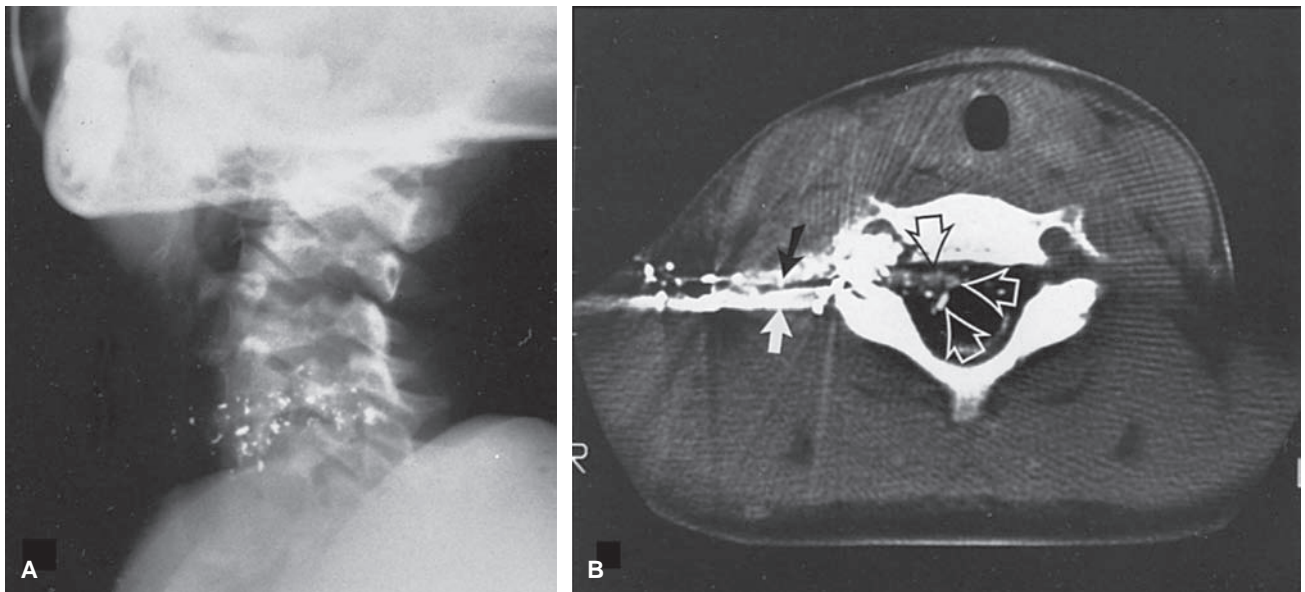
Gunshot wound (.22 caliber) to the neck in a 5-year-old girl. A: Lateral neck radiograph showing fragmentation of bullet along path. B: Computed tomography (CT) scan of same patient demonstrating bullet fragments in and around the spinal canal, as well as cerebrospinal fluid and contrast leak from disruption of the dura.
